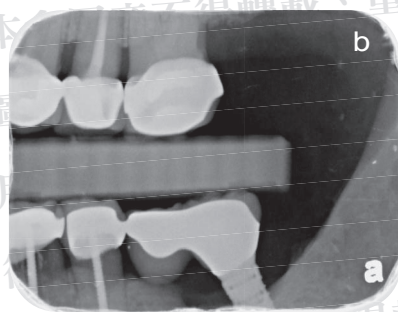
(a) Periapical radiograph before crown removal of tooth #24 on September 23, 2015.
